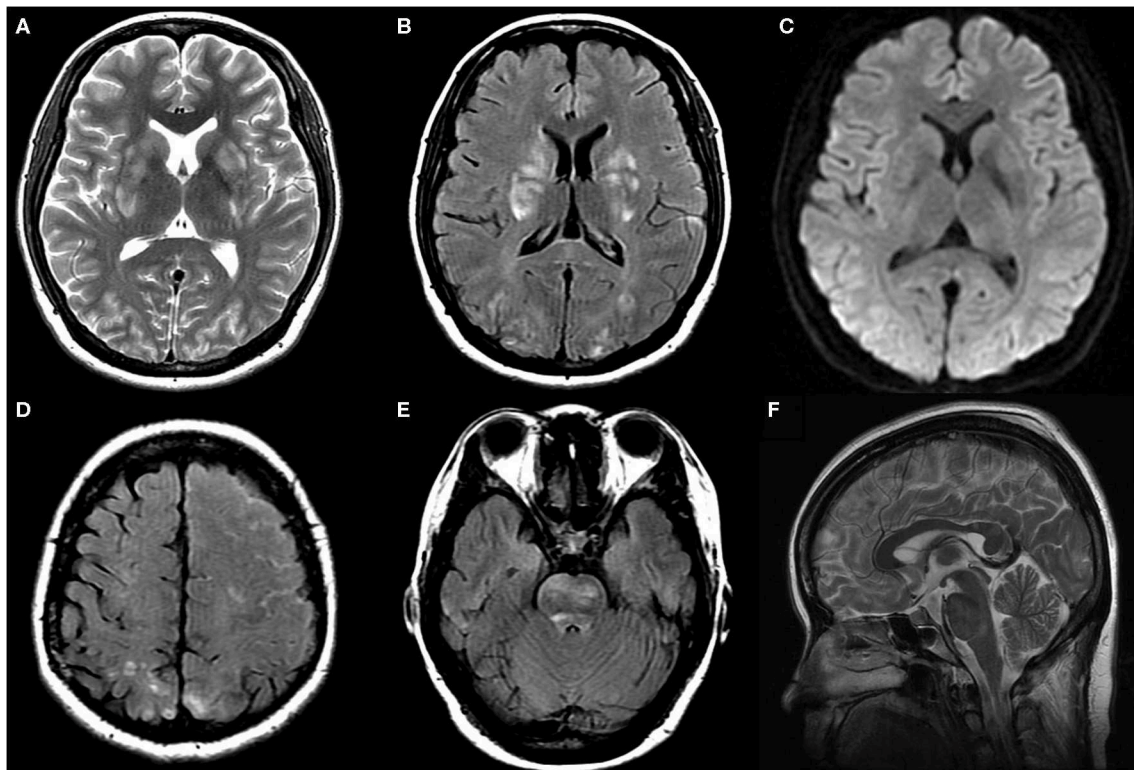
Axial T2WI (A), axial FLAIR (B,D,E), axial DWI (C) and sagittal T2WI (F) images at symptom onset: T2WI, FLAIR, and DWI images demonstrated hyperintensity without diffusion restriction in bilateral parieto-occipital region, basal ganglia, and brainstem. FLAIR images demonstrated left frontoparietal sulcus subarachnoid hemorrhage. Axial T2WI images demonstrated mild enlargement of pituitary and dural sinuses.
